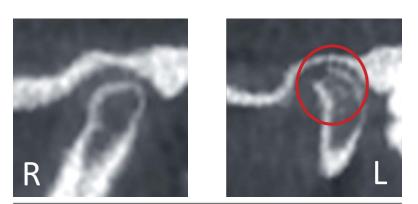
CBCT showing intact and non-intact cortical plate.
